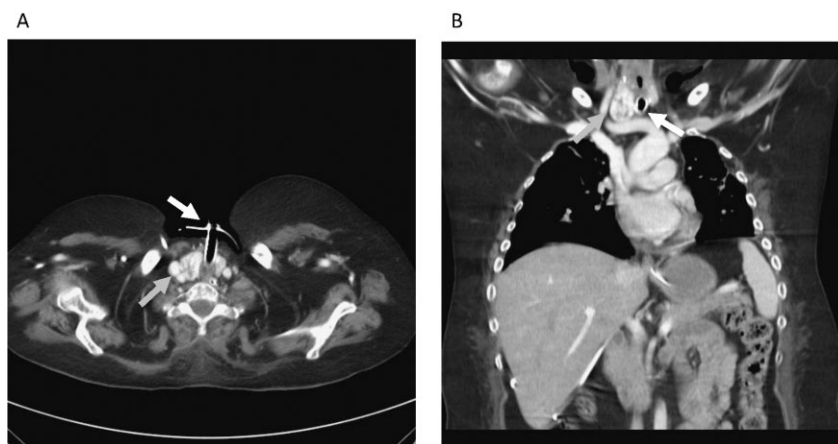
(A) Cross-section and (B) sagittal neck computed tomography showing the tracheostomy tube in place. White arrow: tracheostomy tube; grey arrow: thyroid gland.
